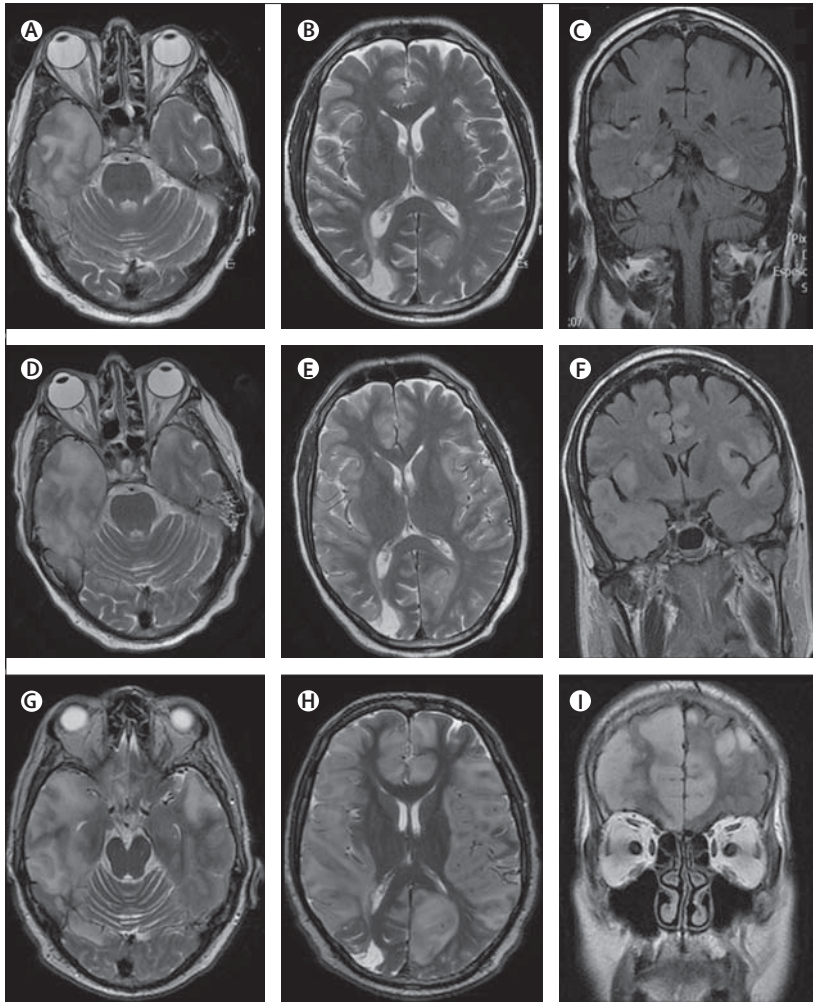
MRI findings in index patient
